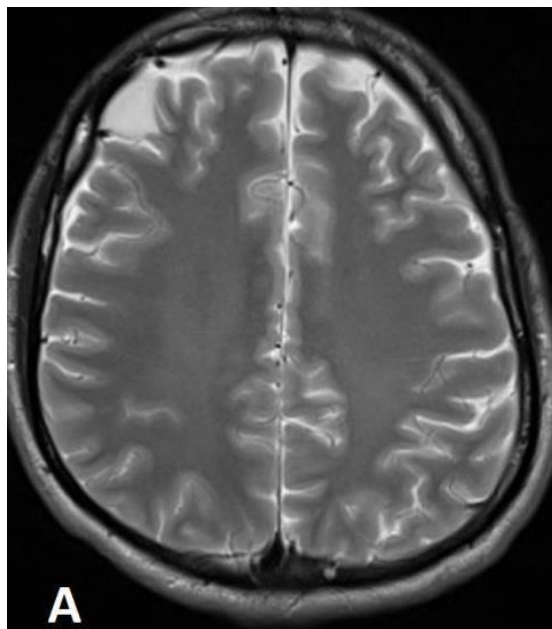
Figure A T2-weighted axial MRI
